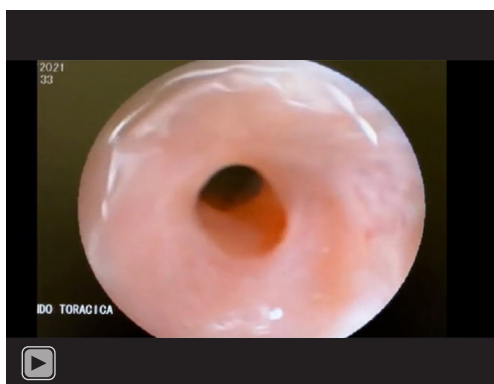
(A) Sub-total tracheal stenosis (arrow) above tracheal cannula, with a residual tracheal lumen of 1–2 mm, about 2.5 cm under the glottis. (B) Pre-operative neck and thorax CT scan with evidence of sub-total tracheal stenosis (arrow) above tracheal cannula.
